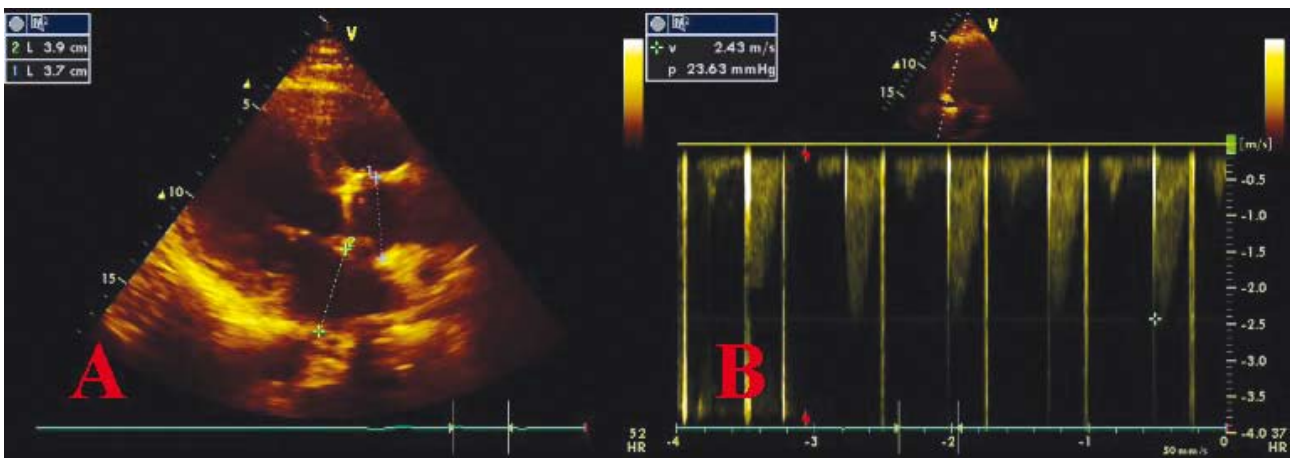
Transthoracic echocardiography study (A, long axis parasternal view) showing no apparent thrombus on the metallic aortic valve, while a Doppler study (B) indicated an acceptable transaortic gradient for the specific type of prosthesis.
